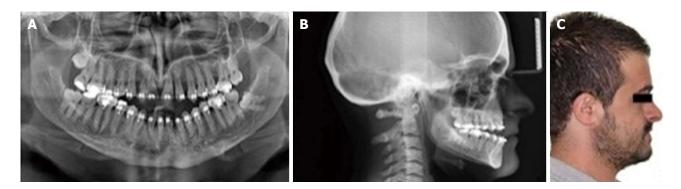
Radiographic and clinical evaluation after orthodontic treatment. A: Panaromic radiography after orthodontic leveling phase; B: Sephalometric radiography shows anterior open-bite malocclusion; C: Profile photograph of the patient after orthodontic leveling phase.
